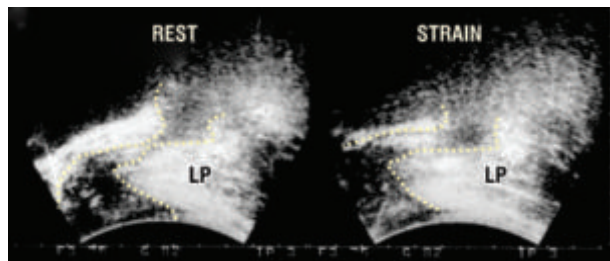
Acute anorectal angle at rest and straining. Transperineal ultrasound. Note excessive forward indentation of the posterior rectal wall at rest. On straining, there is no significant change in the ano-rectal angle; the rectum just above the ano-rectal angle appears to be opened out on straining, rather than narrowed as in Fig. 2.
